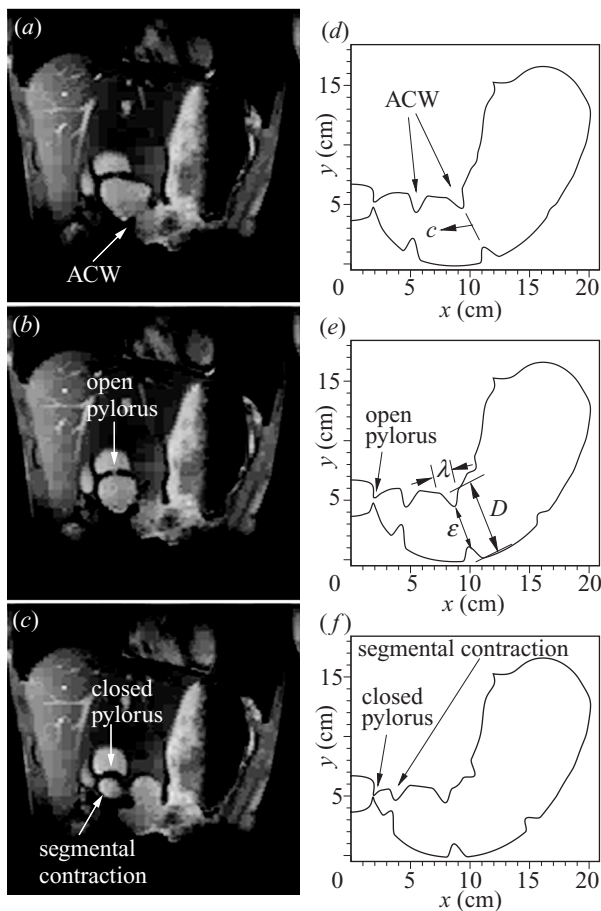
(a–c) MRI images from a movie sequence of the human stomach at 4 s intervals. (d–f) Stomach geometry model at the same 4 s intervals.
